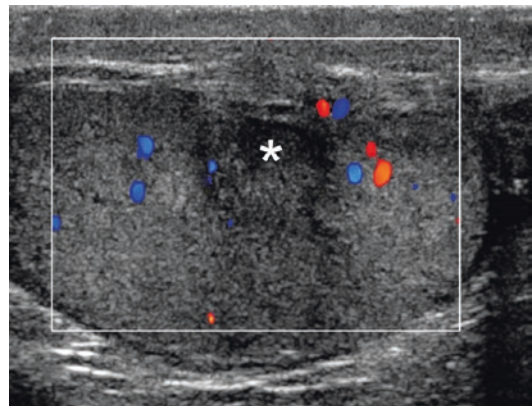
Colour Doppler investigation obtained 6 weeks after the operation shows the postoperative scar (*)
